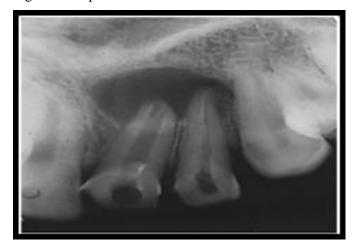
radiograph after gutta-percha removal
